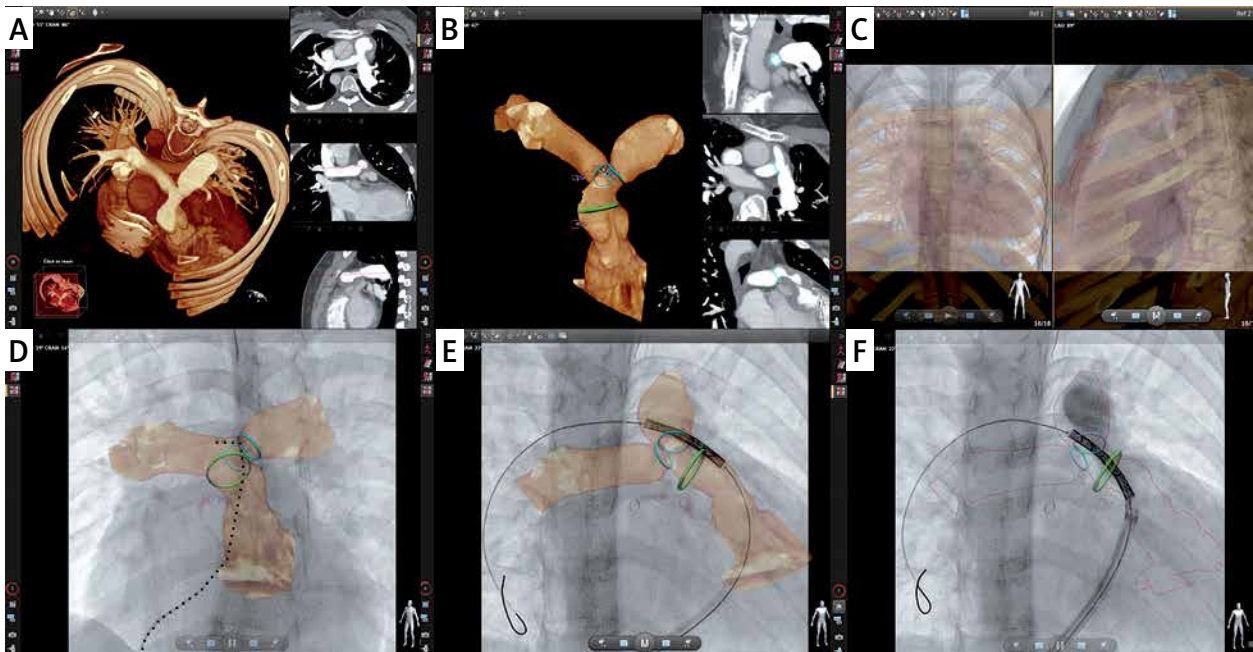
Percutaneous pulmonary valve implantation in a patient with distal conduit and bilateral proximal pulmonary artery stenosis. Automatic three-dimensional (3D) reconstruction and multiplanar reformats from pre-registered computed tomography (CT) were manipulated to outline the conduit and the proximal pulmonary arteries (A). The stent landing zone was marked with one green ring, and the origin of the right and left pulmonary artery with another two blue rings (B). Pink rings indicate ostia of the right and left coronary artery. Bony structures were utilized to enhance manual 3D image fusion with stored fluoroscopy in two perpendicular projections (C). Movement of a soft catheter (black dotted line) within the borders of the 3D roadmap confirmed satisfactory initial alignment (D). Introduction of a stiff wire and balloon/stent assembly resulted in distortion of the anatomy (E) and significant mismatch of the 3D roadmap (F) and actual position of the graft and pulmonary arteries. The remainder of the procedure was successfully conducted with traditional two-dimensional guidance
